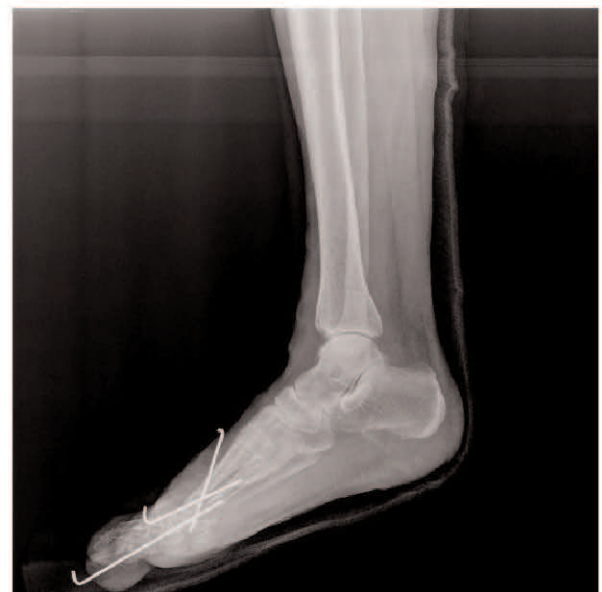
Postoperative lateral x-ray radiography of the same patient.
